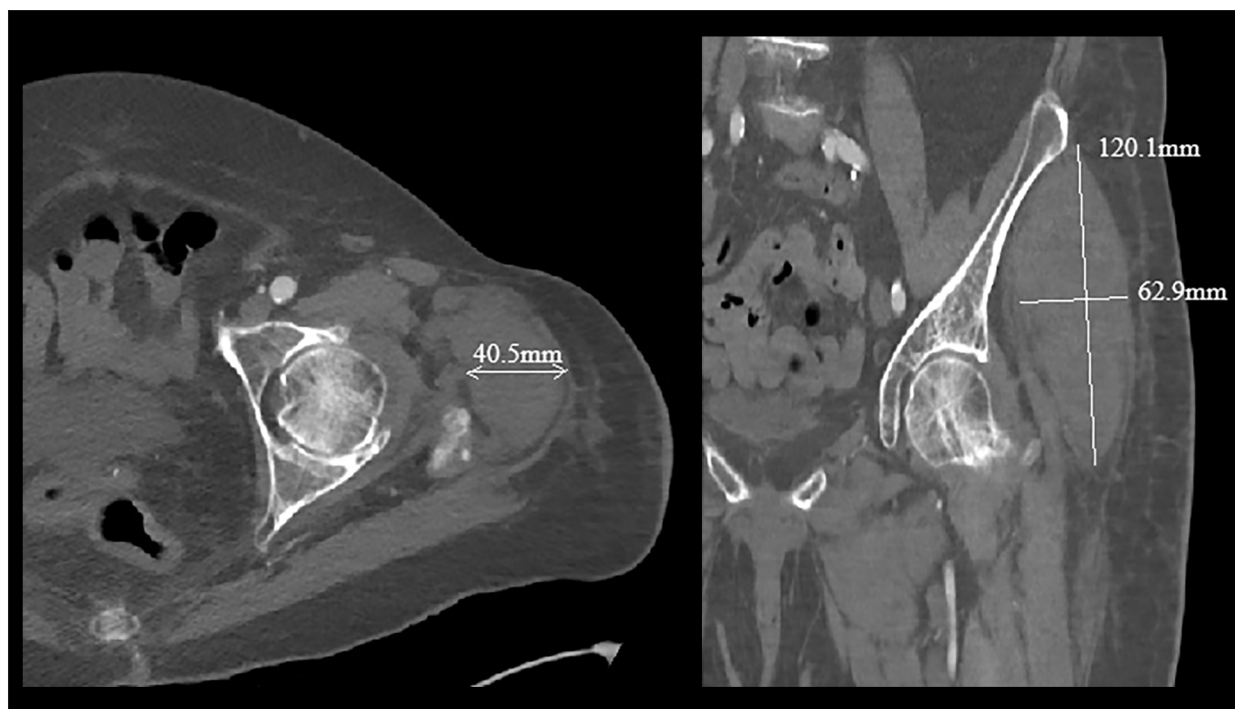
CTA of left lower extremity demonstrating intramuscular hematoma within the left gluteus minimus muscle belly measuring 4.1 × 6.3 × 12 cm in axial (left image) and sagittal (right image) views. CTA, computed tomography angiography.
